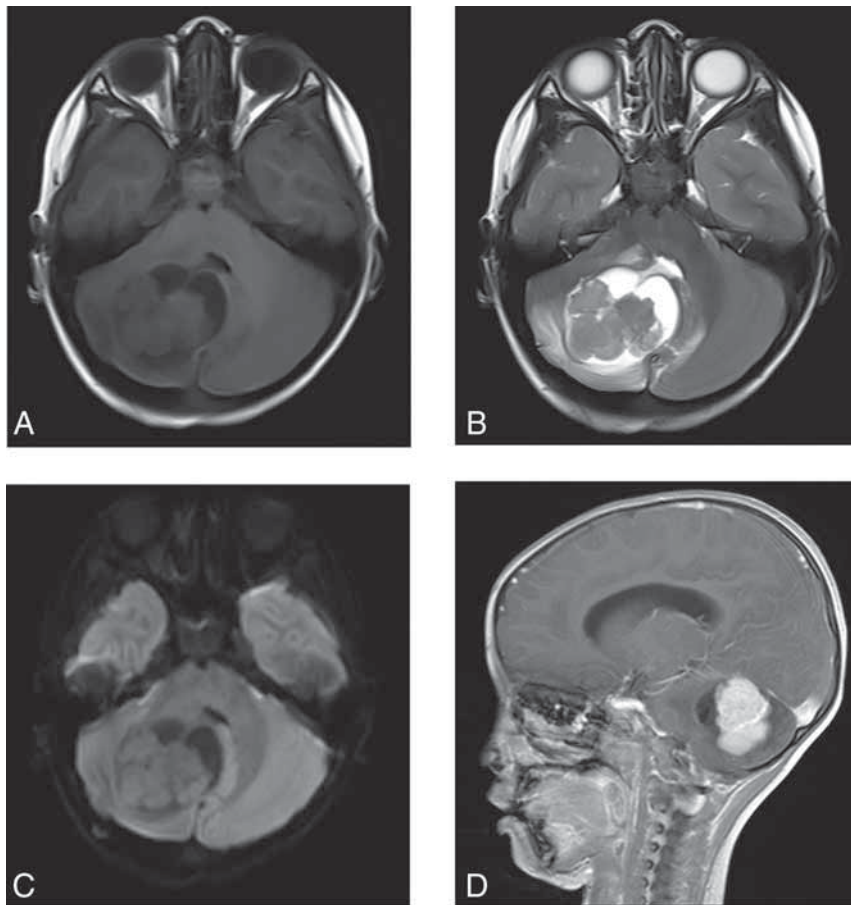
A 4-year-old boy with a right cerebellar hemisphere YST. *A*, MR image shows the tumor located in the right cerebellar hemisphere. It is solid with cystic changes. *B*, There is a small amount of edema around the tumor, and the fourth ventricle is compressed. *C*, DWI shows isosignal of solid components of the mass. *D*, The tumor shows serpiginous enhancement.
